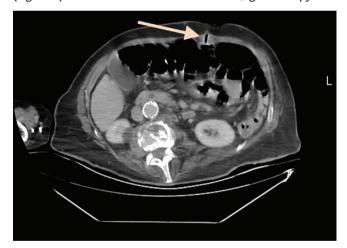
The PEG catheter as seen in the abdominal CT image indicated by the arrow
